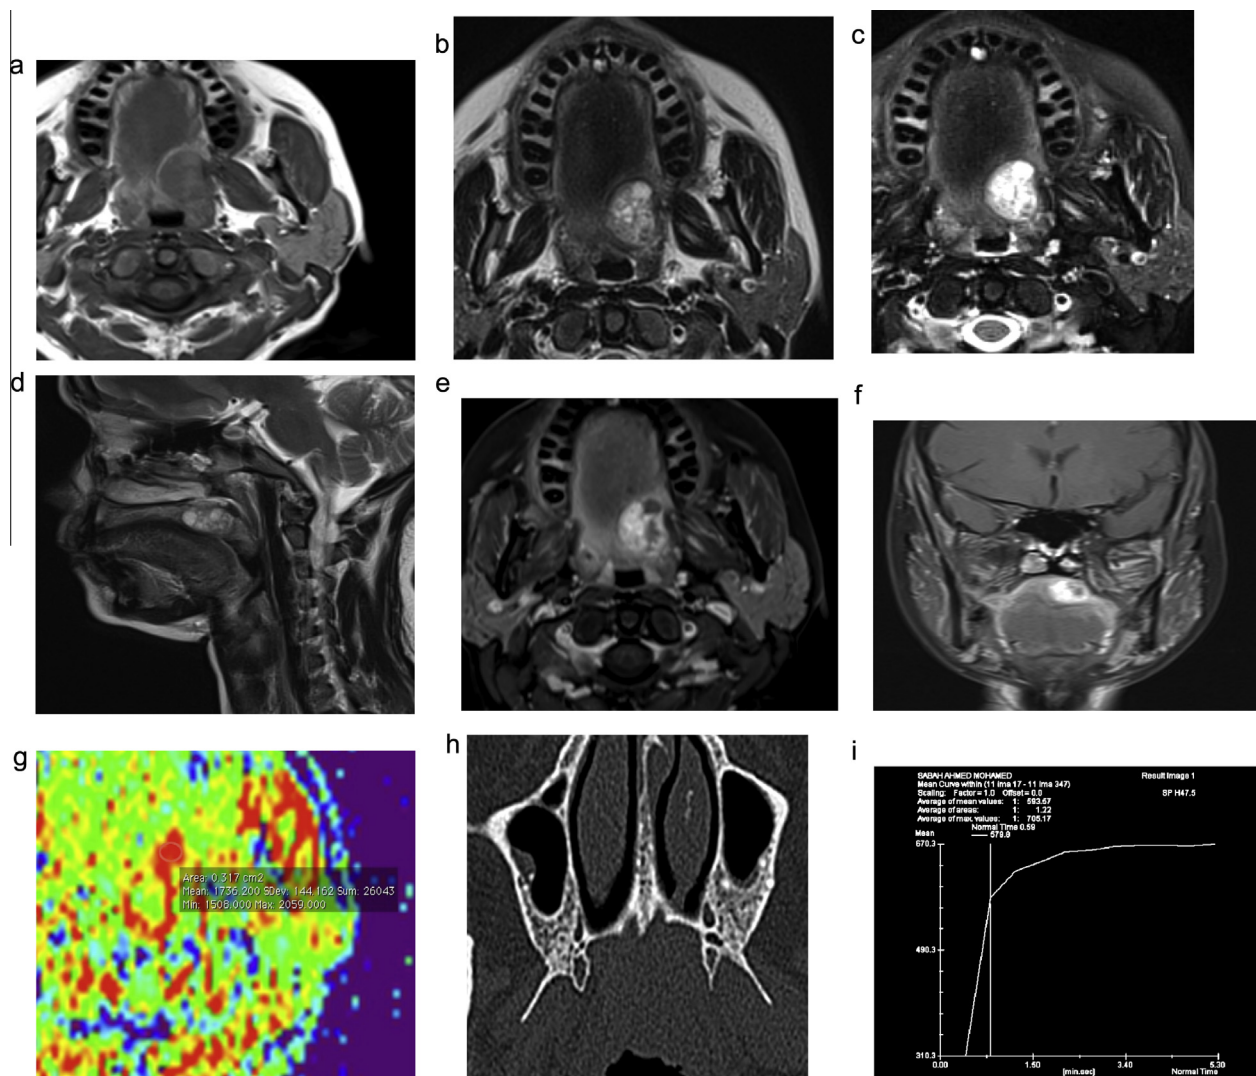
Case 2: Pleomorphic adenoma. A 32 years old female presenting with oral mass and dysphagia. (a) Axial T1 WI shows smooth well-marginated lesion at the left side of the palate. (b) Axial T2WI shows bright signal and thin internal septa. (c) Axial STIR shows more bright signal. (d) Sagittal T2WI shows the lesion at the junction of hard and soft palates. (e and f) Axial and coronal T1 + GAD images showed strong enhancement with cystic changes. (g) Color scale ADC showed high ADC of $1.7 \times 10^{-3} \text{ cm}^2/\text{s}$. (h) Non-contrast CT showed smooth scalloping of the hard palate. (i) Type A curve is displayed by the lesion. Imaging diagnosis suggested pleomorphic adenoma proven later by post surgical biopsy.
